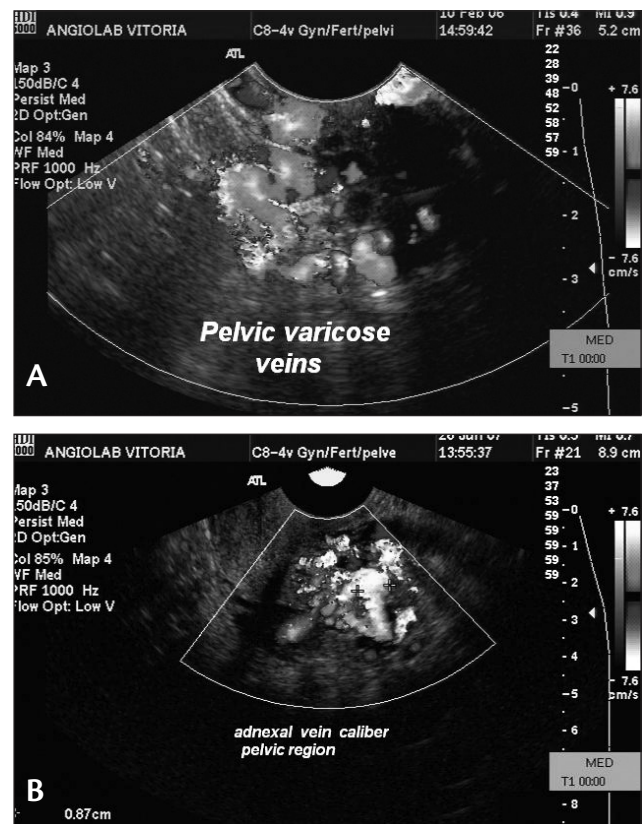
A) Dilated vessels, with reflux, in the adnexal region identified by transvaginal color Doppler ultrasound; B) measurement of adnexal vein caliber, identified by transvaginal color Doppler ultrasound
